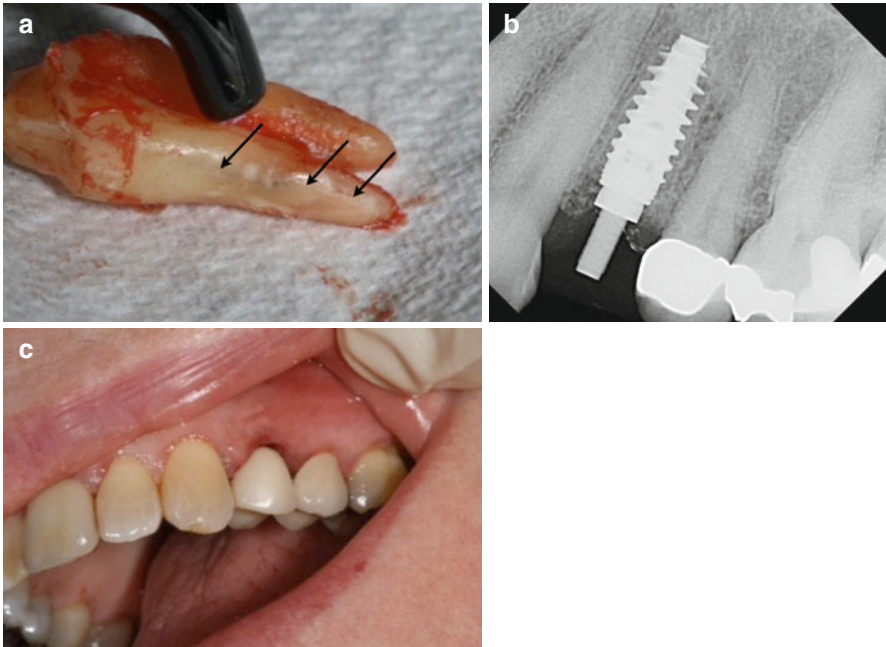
Continuation of case in Fig. 3.4: (a) Tooth #12 after surgical extraction. The *black arrows* are the VRF which corresponds to the area of buccal bone loss in the CBCT. (b) An immediate implant was placed after the extraction. (c) Temporary restoration in place without loading the implant
